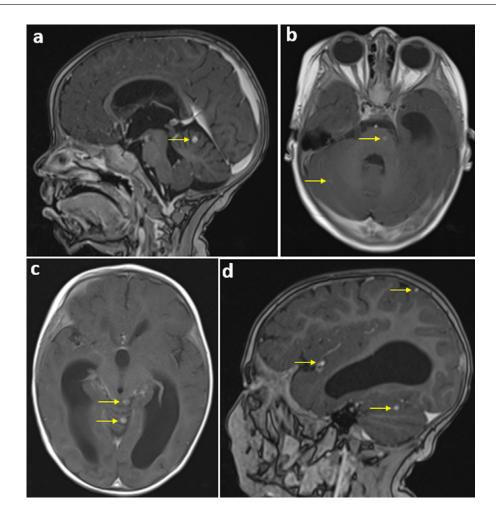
Axial and sagittal sections of a brain MRI in T1 sequence after injection of Gadolinium showing intense and homogeneous enhancement of lesions predominantly at the sub tentorial level at the level of the vermis (a and c), the mesencephalic tegmentum (b) and the cerebellum (b and d).
